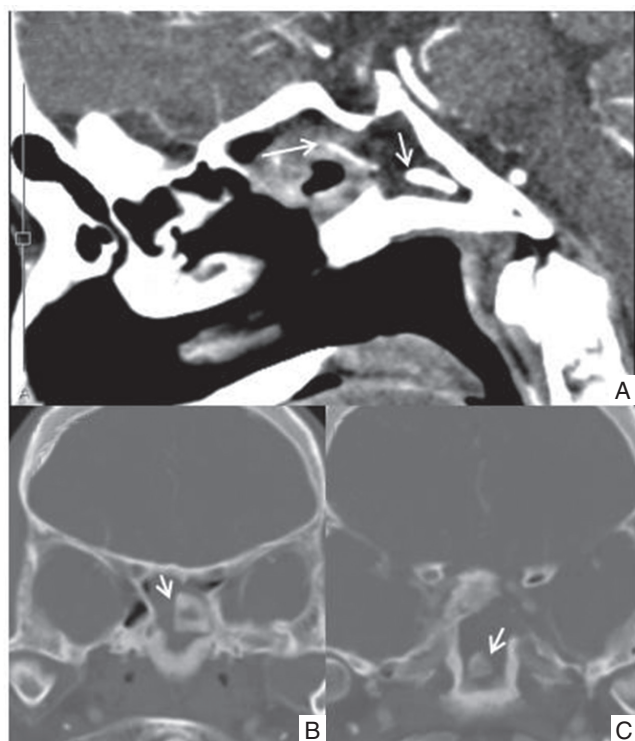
Computed tomography scans on admission (A: sagittal section, B, C: coronal section, bone images) showed that the bone graft was divided into two pieces (arrows) and dropped out into the sphenoid sinus; there was no evidence of skull base destruction with sphenoiditis.
